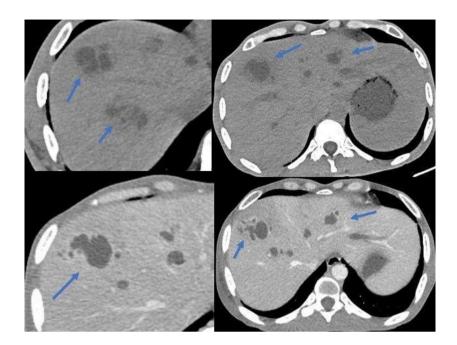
(A-D). Non contrast CT(A,B) and Contrast CT (C,D) reveals multiple hypodense abscesses in right & left lobes of liver
